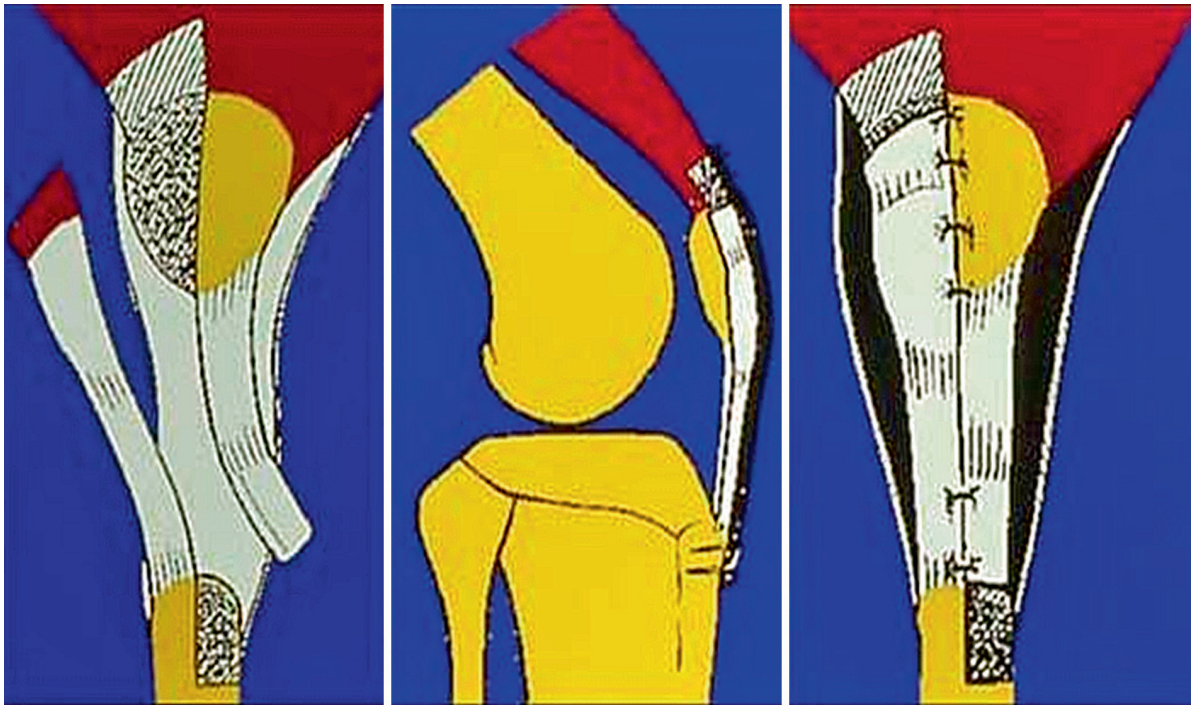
Patellar tendon Lengthening (DeJour). The three steps: (1) Z plasty of the patellar tendon; (2) perioperative x-ray evaluation of the patellar height; (3) fixation with stitches protected with a metallic wire for 6 months
